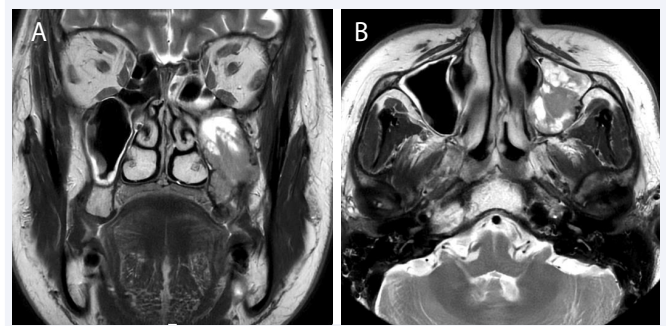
Case 2; (A) Coronal view, (B) Axial view; T1, Gadolinium-enhanced pre-operative MRI of left maxillary sinus AM measuring 2.3 x 2.7 x 2.8cm. Expansion of tumor from the left 2nd molar with involvement of the left pterygoid plates; hyper-densities visible within AM tumor.
